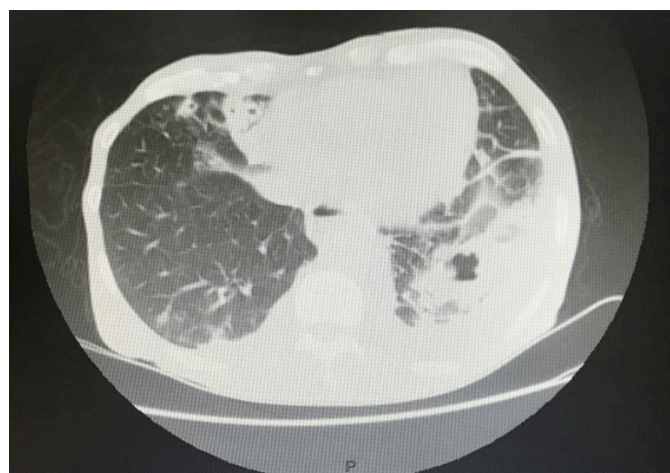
Chest computed tomography scan showing worsening of cavitary lesions with patchy infiltrates.
